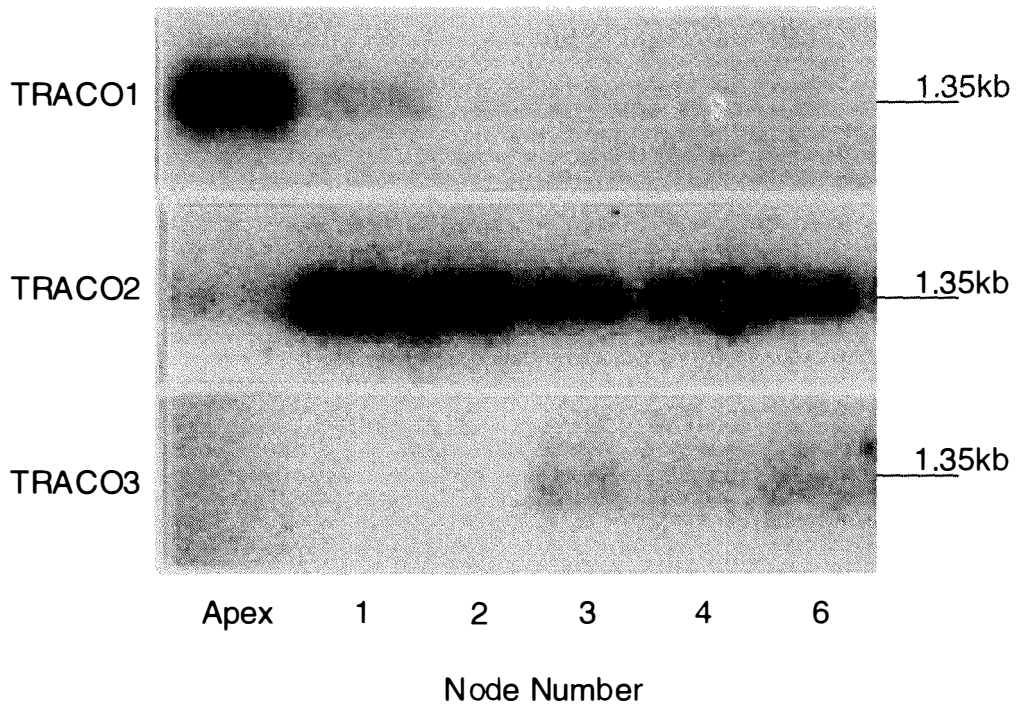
Expression of ACC oxidase genes in leaf tissue at different stages of development determined by northern analysis using 3' UTRs as probes. Two μg of poly(A)⁺mRNA was separated on a 1.2 % (w/v) agarose-formaldehyde gel, blotted onto Hybond-N⁺ with alkaline transfer buffer, probed with ³²P-labeled 3'-UTR of TRACO1, TRACO2 and TRACO3 (as indicated), and washed at high stringency (0.1 X SSPE at 65 °C). The membrane was exposed to X-ray film for 7 days.
